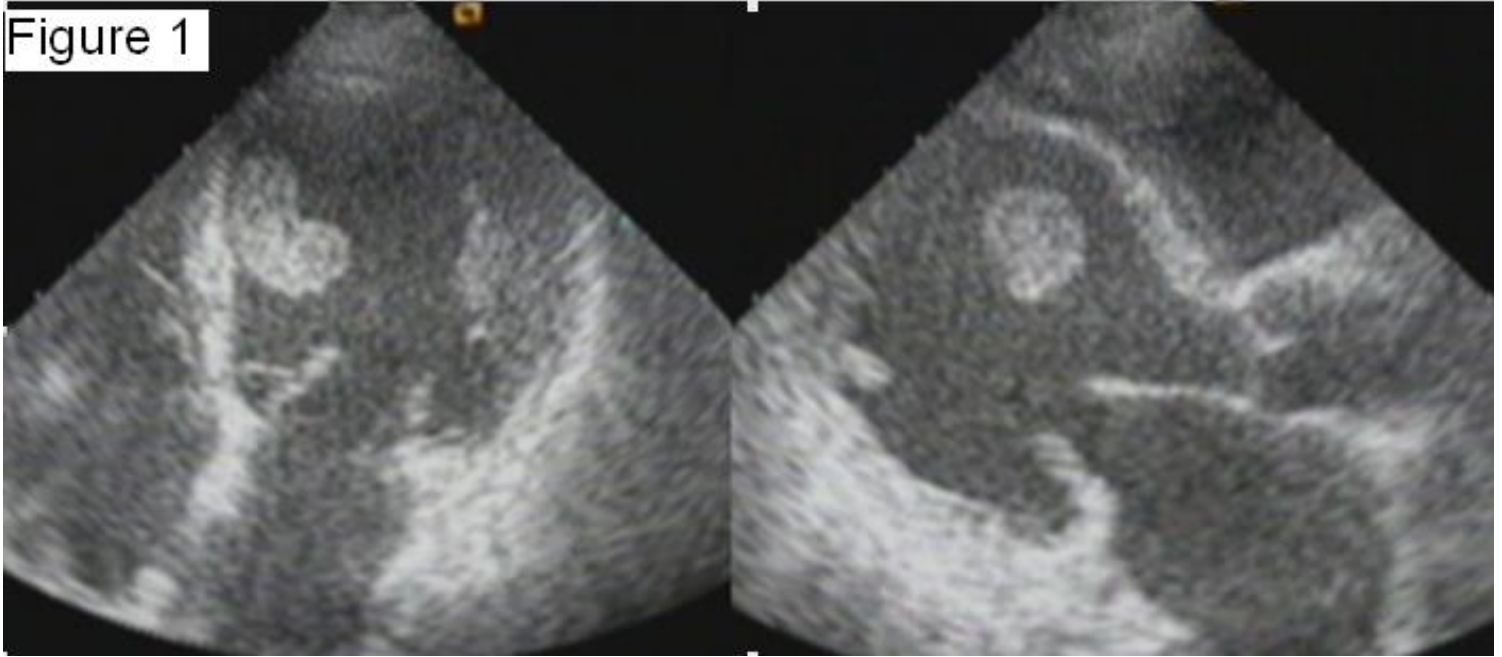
Transthoracic echocardiography showed a handle, smooth contoured giant mass measuring 27x32 mm in the left ventricle
